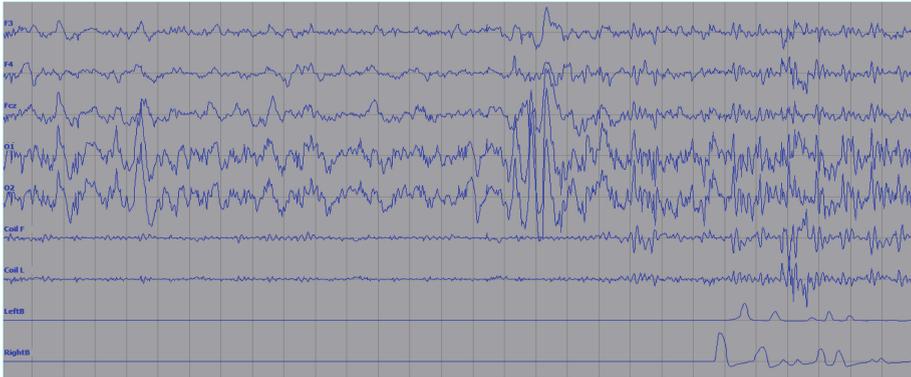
An example of the EEG of the moment of awakening and the preceding slow-wave activity (after MRI gradient and cardiobalistic artifact correction).
